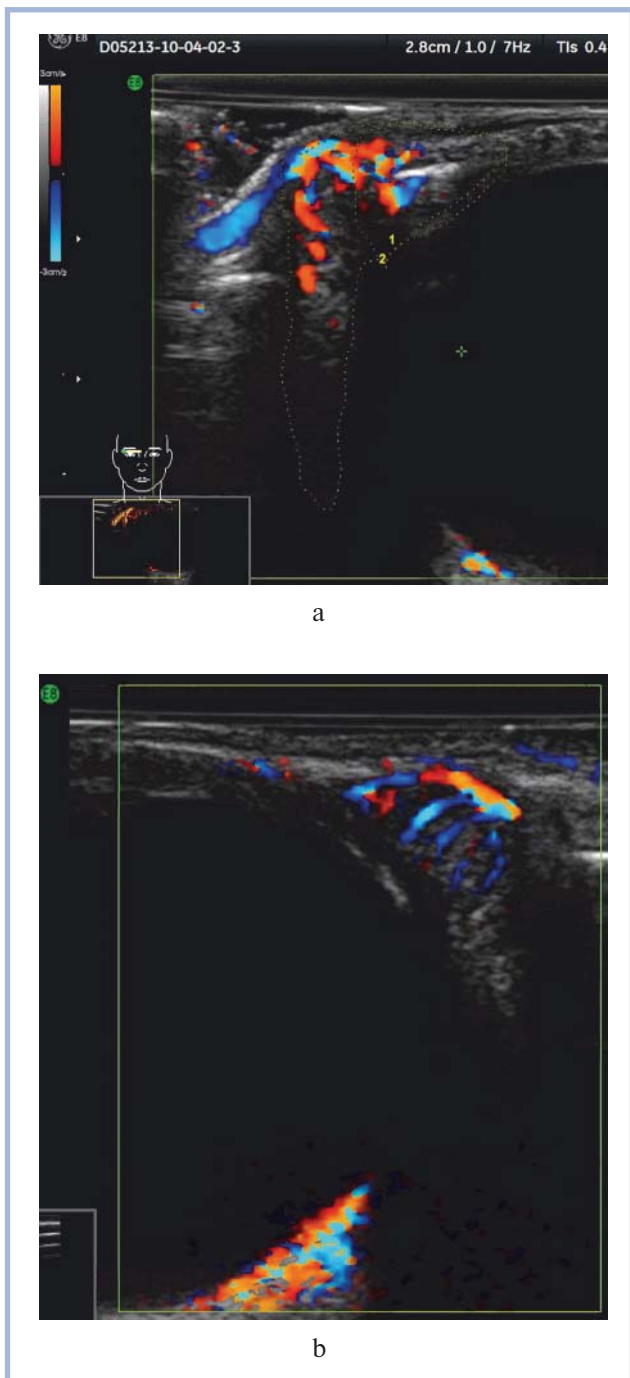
A combined ultrasound examination of the right (a) and left (b) lacrimal glands. Local accentuation of vascular pattern around a rarefaction zone in the palpebral lobe on color mapping (red for arterial, blue for venous blood flow). Significant intensification of venous blood flow.
